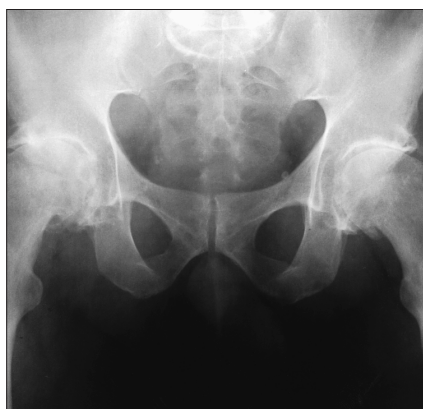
Radiograph of the hips of the 65-year-old man before hip replacement.
